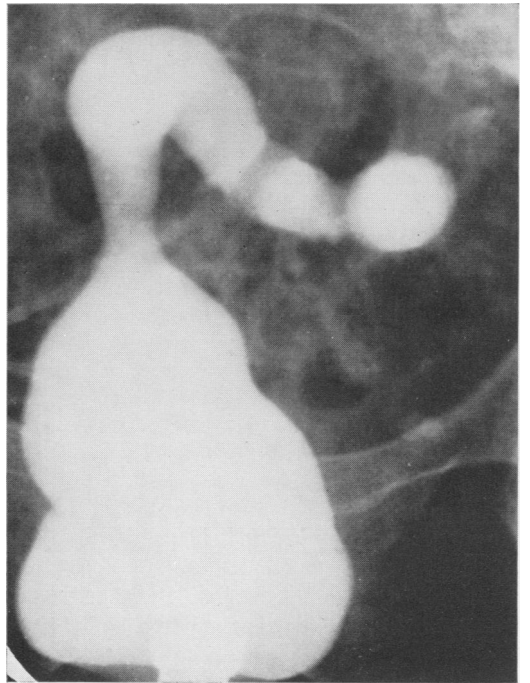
On barium enema x-ray, a smooth, fixed narrowing in the rectosigmoidal area over a distance of 2 cm. was interpreted to be consistent with late radiation fibrosis with stenosis.
